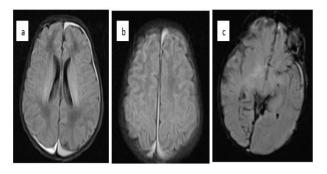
MRI brain images; (a) Axial T2 FLAIR image showing bilateral parietal and left frontal convexity subdural hematoma, (b) Axial T2 FLAIR showing interhemispheric subdural haemorrhage, (c) SWI sequence showing blooming along sulci in right occipito-temporal and left temporal lobe suggestive of subarachnoid haemorrhage; Small foci of blooming in bilateral lateral ventricles suggestive of intraventricular haemorrhage.
